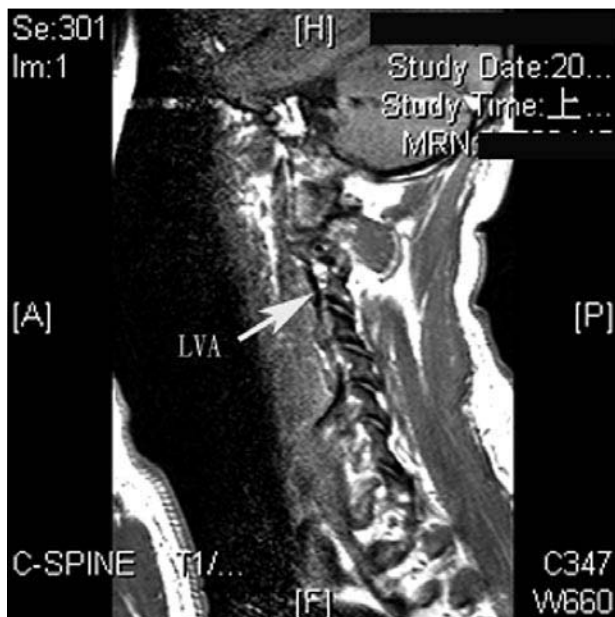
Preoperative magnetic resonance imaging showed that both vertebral arteries were intact, while the left vertebral artery (LVA) was in the vicinity of the abscess.
